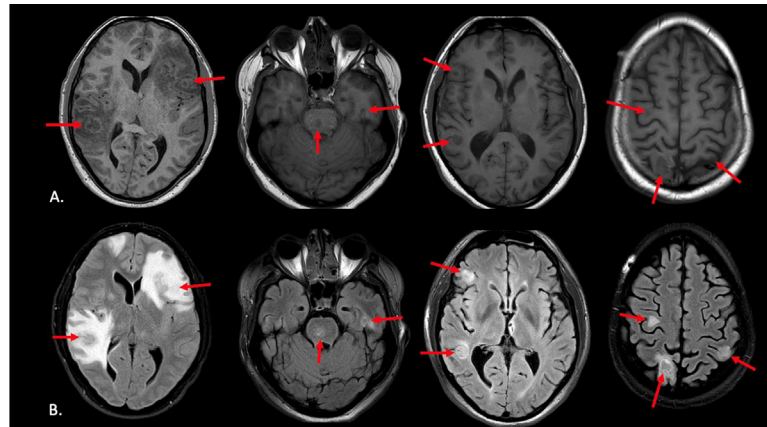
Row A. shows axial sections of T1 weighted MRI, which reveals hypointense to isointense PCNS-PTLD lesions (red arrows). Row B. shows axial sections of a T2 FLAIR weighted MRI, which reveals the corresponding lesions primarily as T2 hyperintense (red arrows).
